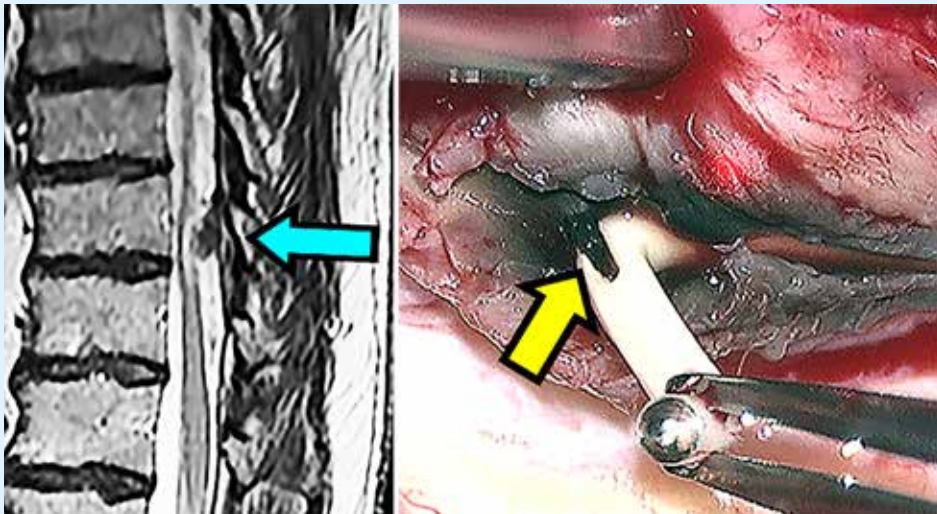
A granuloma (A, blue arrow). Tremendous in vivo ingrowth with an abnormal black colouring (B, yellow arrow). The patient complained of exacerbation of pain in his legs without neurological signs. The causes can easily be overlooked when MRI is limited to the lumbar area.
